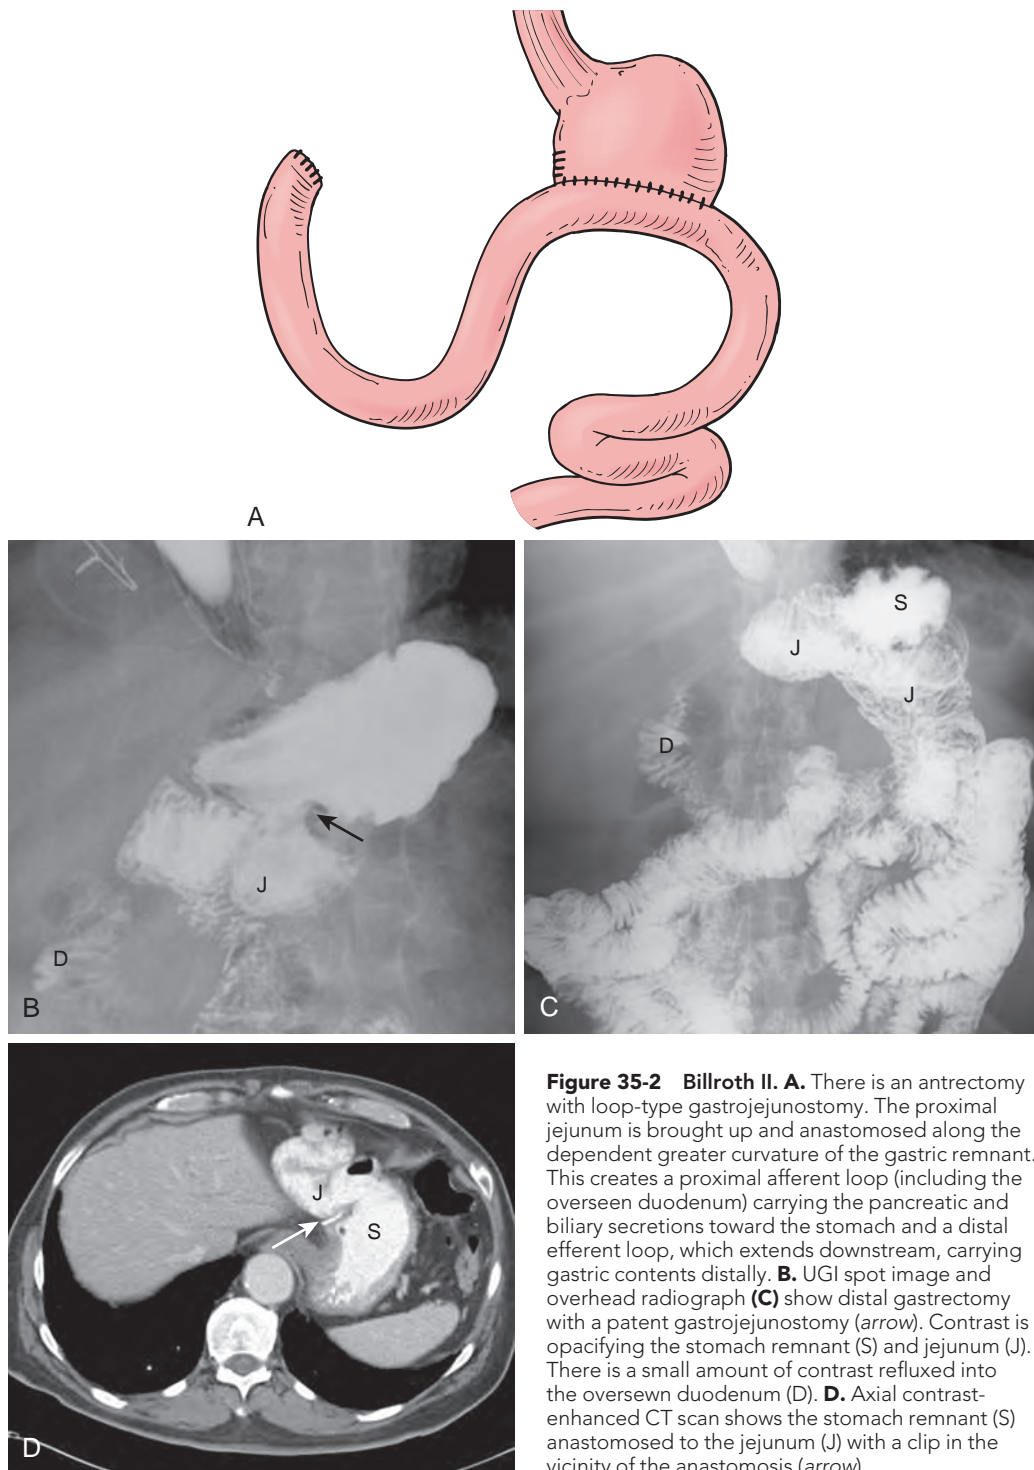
Billroth II. A. There is an antrectomy with loop-type gastrojejunostomy. The proximal jejunum is brought up and anastomosed along the dependent greater curvature of the gastric remnant. This creates a proximal afferent loop (including the oversewn duodenum) carrying the pancreatic and biliary secretions toward the stomach and a distal efferent loop, which extends downstream, carrying gastric contents distally. B. UGI spot image and overhead radiograph (C) show distal gastrectomy with a patent gastrojejunostomy (arrow). Contrast is opacifying the stomach remnant (S) and jejunum (J). There is a small amount of contrast refluxed into the oversewn duodenum (D). D. Axial contrast-enhanced CT scan shows the stomach remnant (S) anastomosed to the jejunum (J) with a clip in the vicinity of the anastomosis (arrow).
